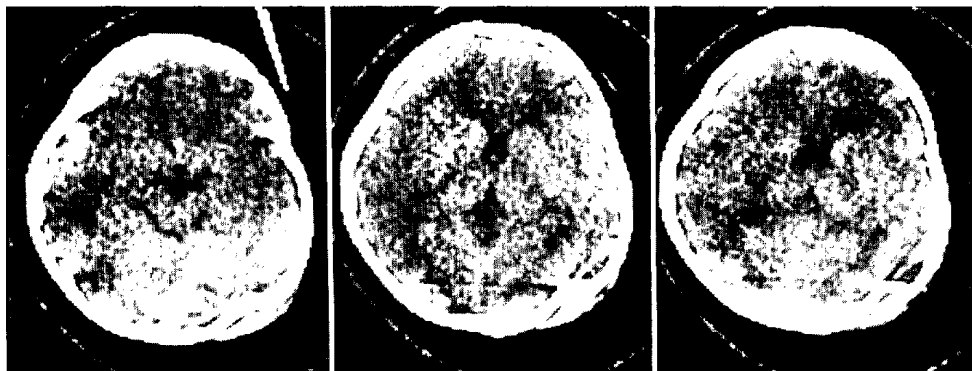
Cerebral contusion. 6-year-old boy. CT was taken a day after trauma. Ill-defined low density areas are seen in the white matter of both frontal lobes. This pattern is called "poodle's face appearance" (center of the pictures).
